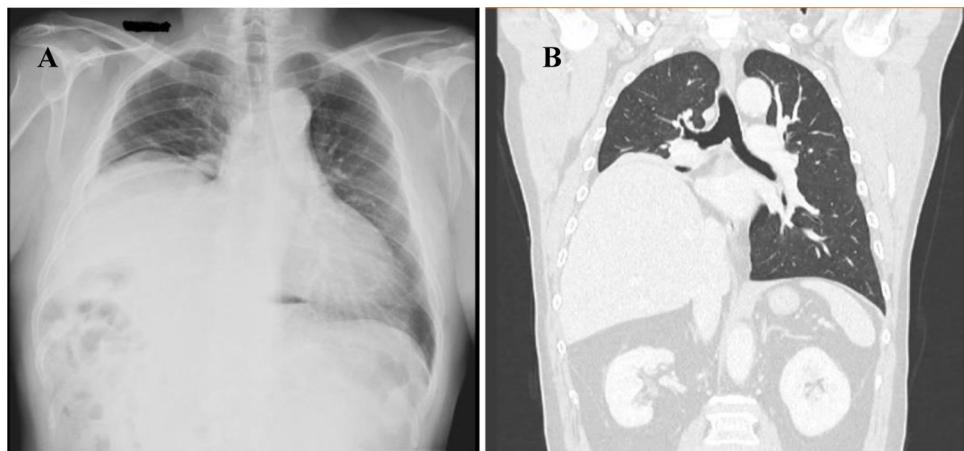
Chest X-ray (A) and thoracoabdominal computed tomography (B) with an important rise in the right diaphragmatic dome evoking a diaphragmatic paresis.
